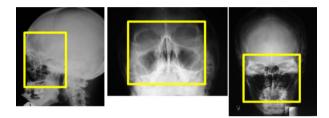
A series of radiographs which were supposed to only image the paranasal sinuses (yellow collimation lines); instead, almost the whole head was X rayed. (Images courtesy of E. Ho, Sime Darby Medical Centre Park City, Malaysia.)
